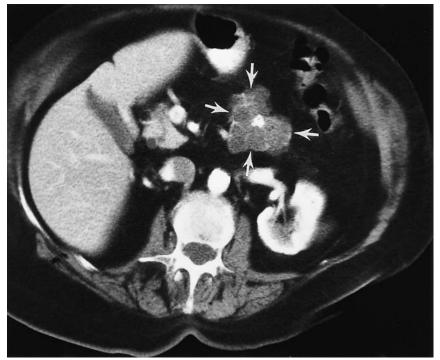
Cystic neoplasm. In patients with a history of pancreatitis, increased serum amylase levels, and CT findings characteristic of pancreatitis, such lesions are suggestive of benign pseudocyst. Neoplasm can be ruled out definitively with biopsy. These cystic neoplasms have septa and some have central calcification (arrows). (Courtesy of Henry I. Goldberg, MD.)
